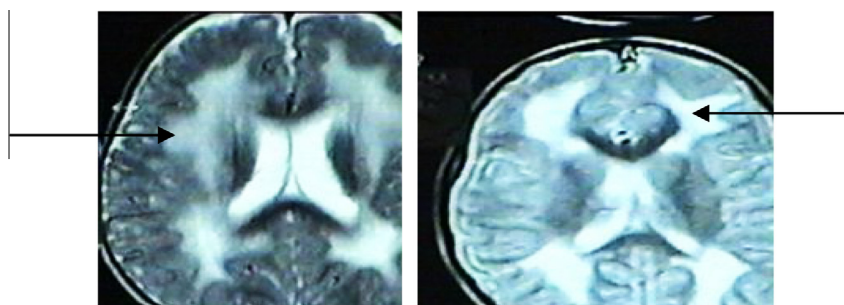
Brain MRI of Case 8 showed extensive demyelination changes of both cerebral hemispheres appearing as high signal intensity on T2WI images (arrows).
